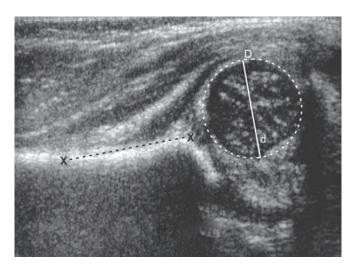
Ultrasonography of subluxation of hip
